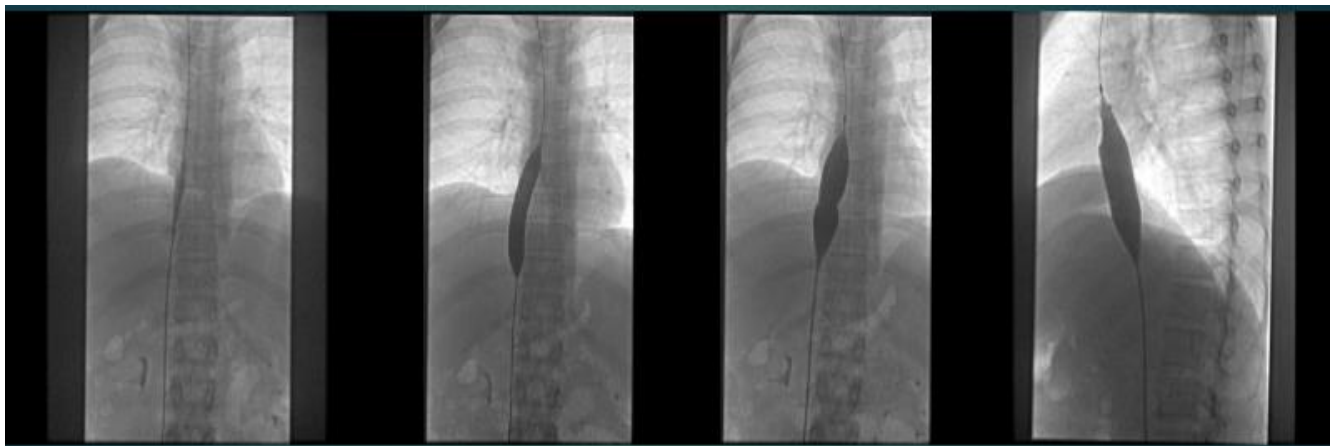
X-ray taken while balloon dilation was being done: Images showing stenting being done with serial balloon dilation (in the images it can be seen that the balloon that is seen as dark black, is dilated gradually to establish the patency of the blocked vessel).
